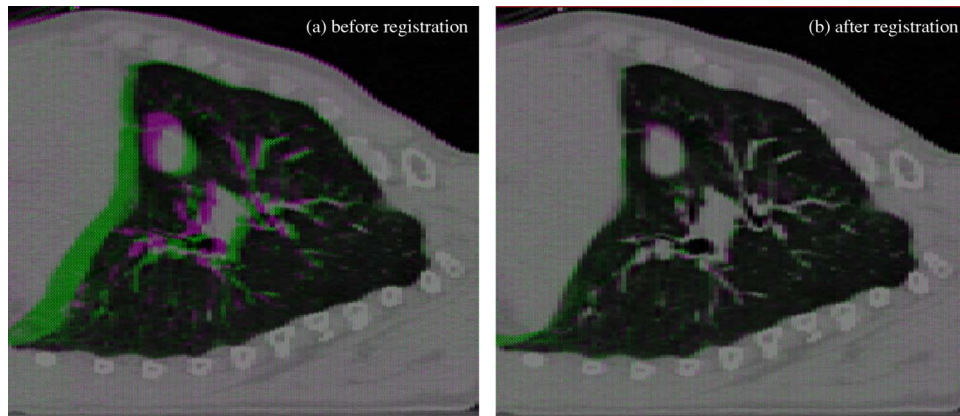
The data set of Fig. 3, shown as (a) overlay of exhale and inhale CT before registration, and (b) after registration (inhale CT deformed to exhale CT using the deformation field).
